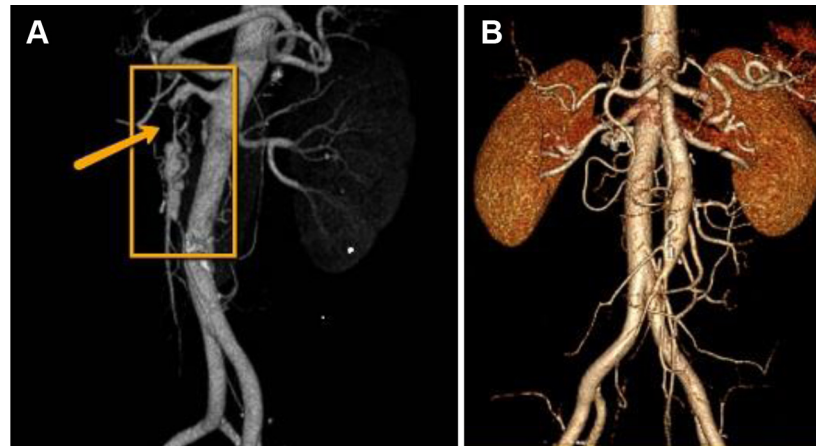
A, Preoperative computerized tomographic arterial (CTA) imaging shows superior mesenteric artery (SMA) dissection. B, Patent SMA on CTA imaging 4 years after intemectomy.
